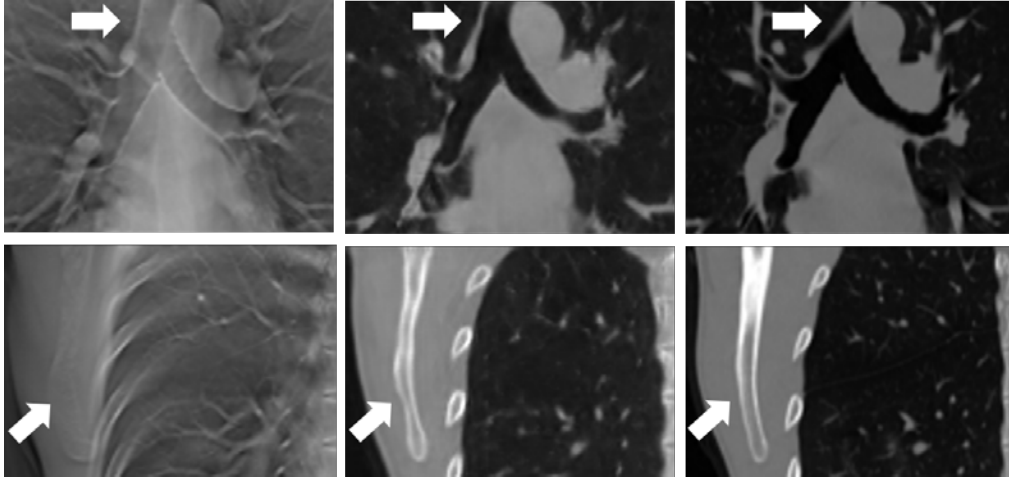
Zoomed ROIs from coronal slices in Fig. 6: FDK-based reconstruction (left), prediction (center) and CT (right). White arrow highlights structures wrongly.
